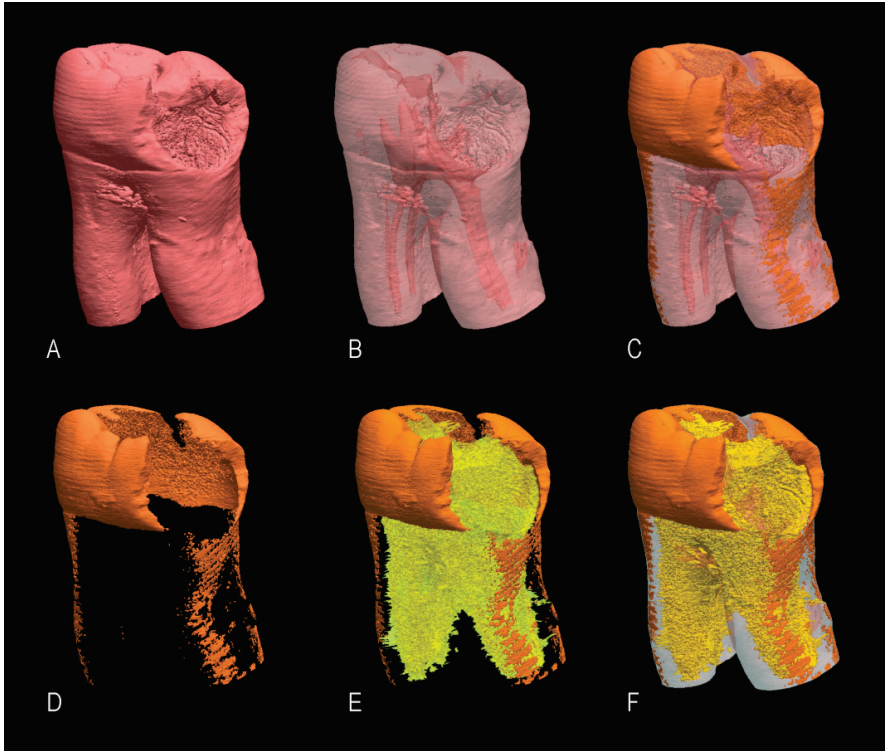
Visualization of 3D micro-computed tomography (CT) models of a caries affected human molar (in pink, A) showing different partly transparent and combined 3D structures as root channels (B), enamel (in orange, C and D) and dentin (in yellow, E).(F) Combined image from transparency of (A) together with (E). Segmentation was based on greyvalue threshold settings of the different radiopaque structures of interest.
